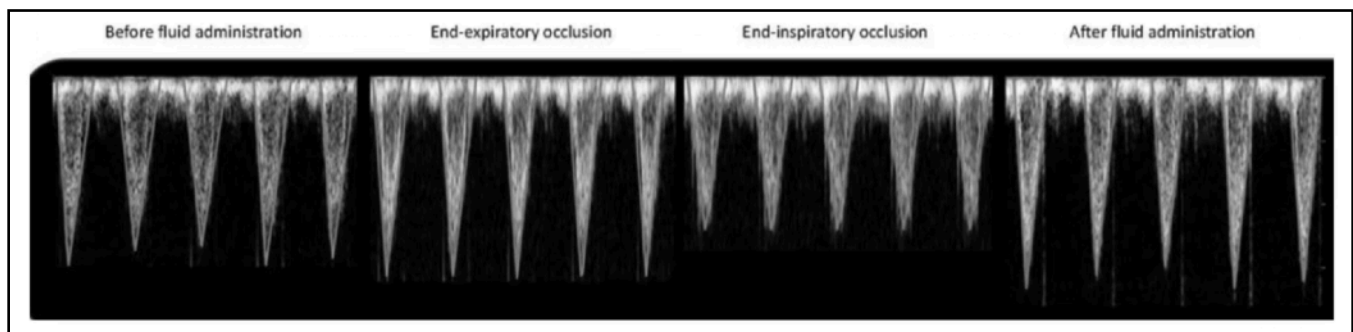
Doppler waveform demonstrating changes in LVOT VTI during end-expiratory and end-inspiratory occlusion tests.
